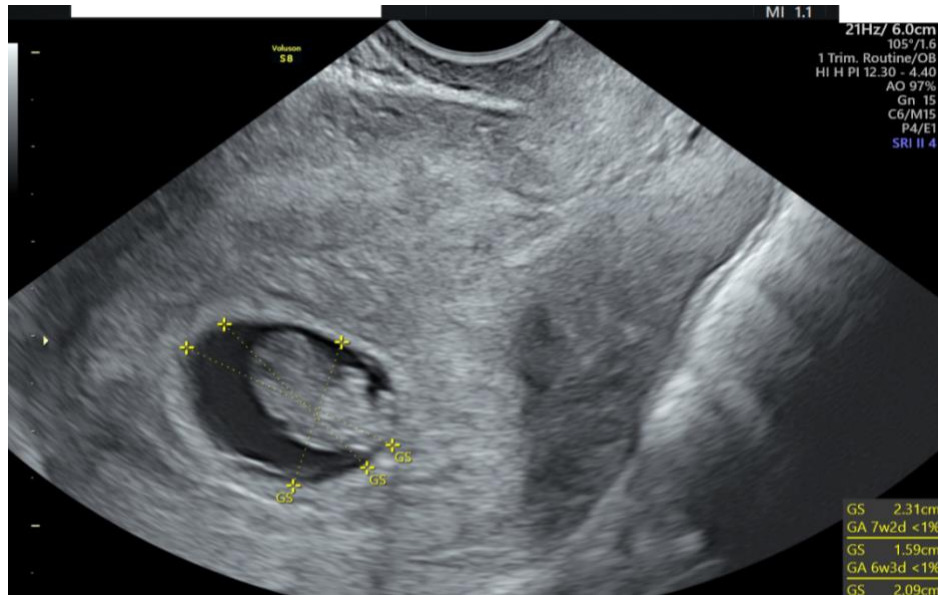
Transvaginal ultrasound at 8+1 weeks of gestation demonstrating the mean gestational sac diameter (GS)
